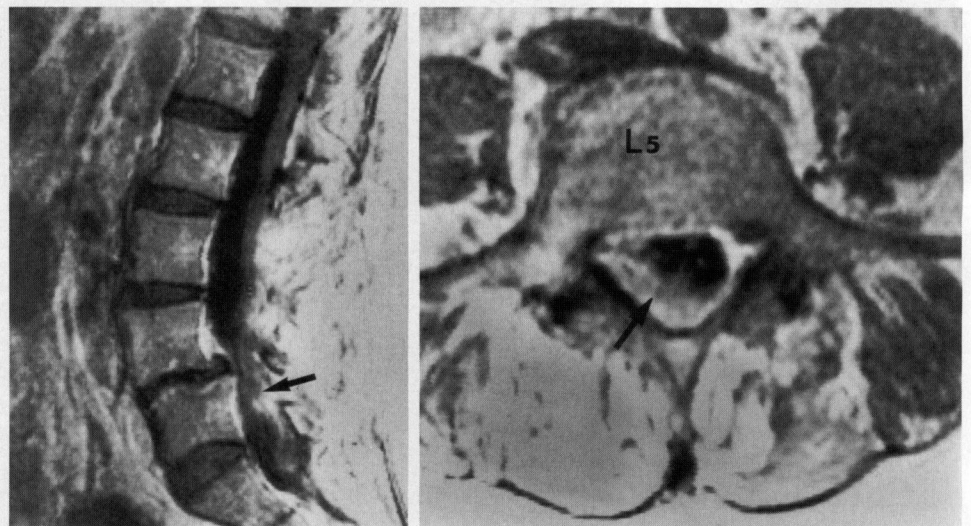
Case 1 (continued). (g, h) Follow-up postcontrast T1-weighted images were obtained 5 days after initiation of antibiotic therapy. (g) On the sagittal section, the collection of pus (*P*) in the anterior epidural space has decreased in size, and the normal cerebrospinal fluid signal intensity in the subarachnoid space (white arrow) is now better visualized due to decreased epidural mass effect. Enhancement along the dura mater and vertebral bodies is still present (short black arrows). At the L4-5 level, there is a low-signal-intensity mass in the dorsal epidural space obliterating normal epidural fat (long black arrow). (h) On the axial section, unenhancing pus in the dorsal epidural space is surrounded by linear enhancement (arrows). Note the minimal enhancement of the left psoas, indicating residual inflammation due to the retroperitoneal abscess (*). (i, j) Postcontrast sagittal T1-weighted images of the lumbar and thoracic regions obtained 2 weeks later demonstrate marked improvement in visualization of the subarachnoid space, particularly in the lumbar region. The subarachnoid space posterior to the thoracic cord is now visualized (black arrows in j), but cerebrospinal fluid anterior to the cord is not seen, suggesting residual anterior epidural abscess. The anterior and posterior SEA has nearly resolved in the lumbar region. Minimal linear enhancement is noted in the upper thoracic epidural area (white arrows in j). Prominent enhancement along vertebral bodies and basi-vertebral veins persists in the lumbar region (arrowheads in i). (k, l) On postcontrast sagittal T1-weighted images obtained 3 months later, the subarachnoid space of the lumbar and thoracic regions is clearly observed, and only minimal enhancement is noted in the basi-vertebral veins (arrowheads in k). The patient was symptom free and ambulatory without assistance.
